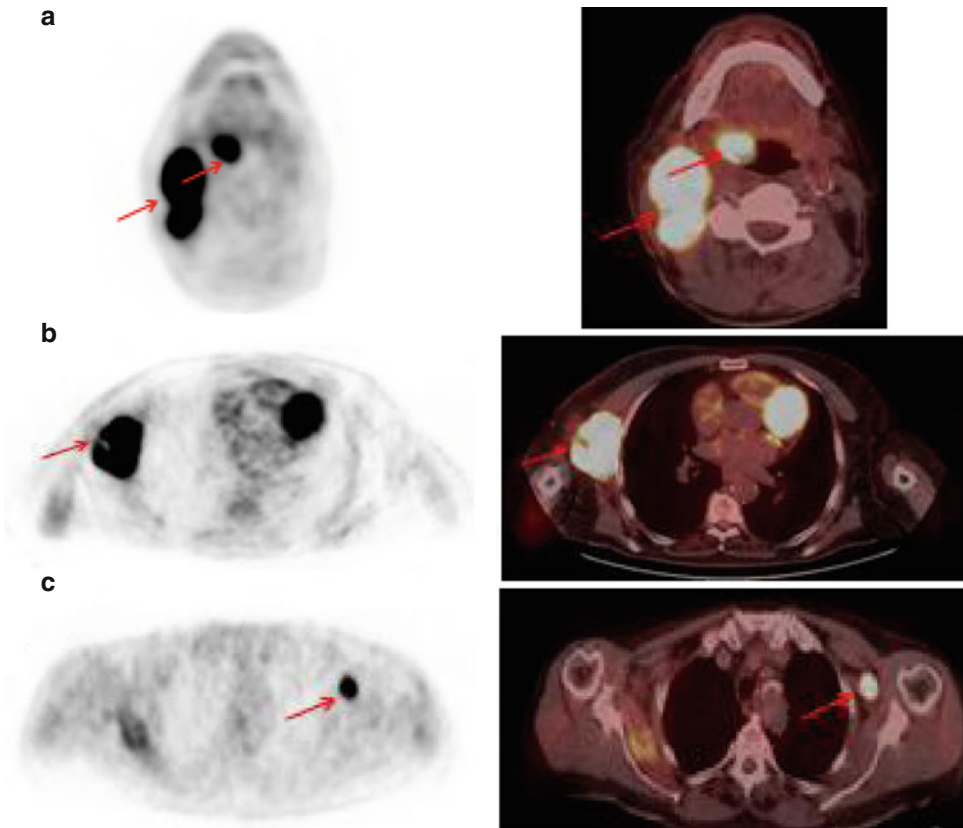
PET and fused PET/CT – initial staging: Hypermetabolic lesions in *right* cervical nodal mass and tonsil (a), axillary lymph nodes (b, c), *right* pulmonary
